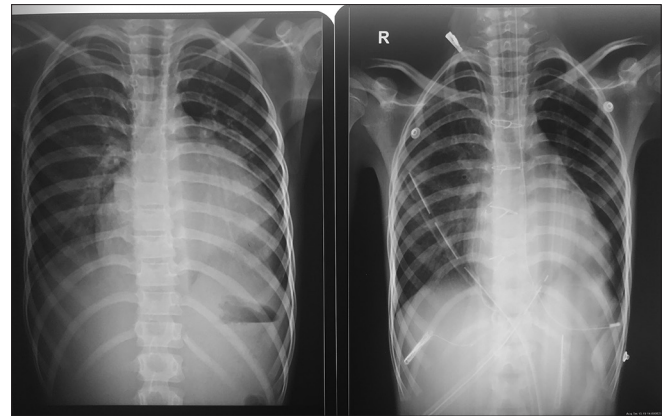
Pre- and post-operative chest X-ray showing the cardiac contour
